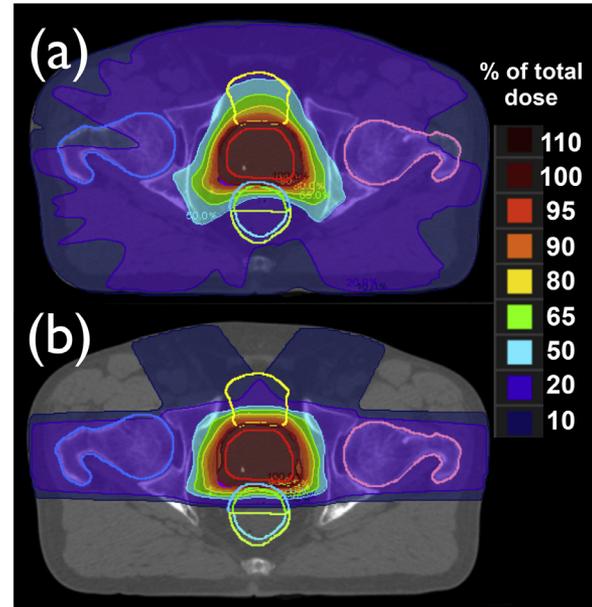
Proton vs. intensity-modulated photon prostate radiation plans. Identical cross sectional computed tomography images of the pelvis showing the prostate (outlined in red), bladder (yellow), rectum (light blue/green), and bilateral femoral heads (dark blue and pink) outlined. The color wash shows the radiation dose (in %) being deposited to any given area. The prostate is receiving 100% of the dose. A) The intensity modulated radiation therapy plan shows much of the cross section receiving a “low-dose bath” of at least 20% of the dose (in purple) whereas B) shows the proton plan, which spares many of the normal tissues, such as large parts of the rectum, of this low-dose radiation. (Color version of figure is available online.)
